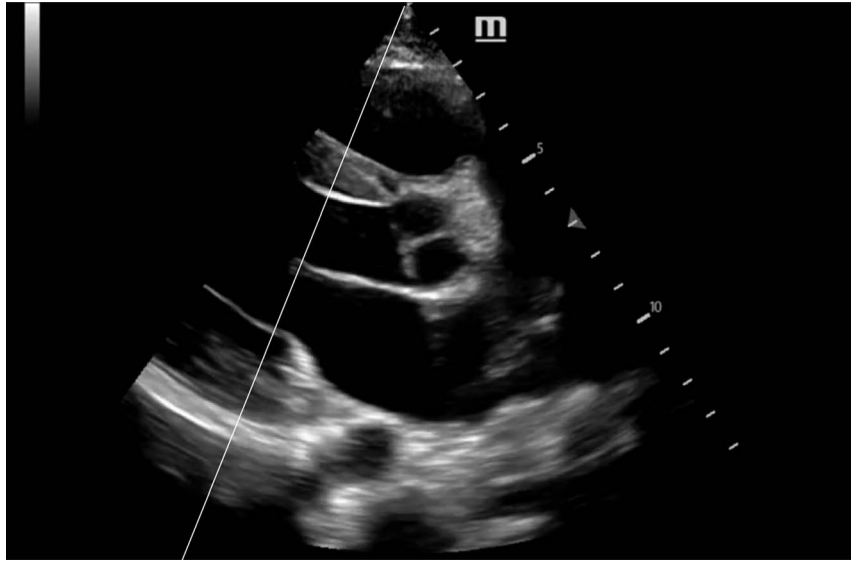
Parasternal long axis view. The white line represents where one would ideally place M-mode to obtain the EPSS (supplemental video media attached, Video 2, <http://links.lww.com/PEC/A786>).
